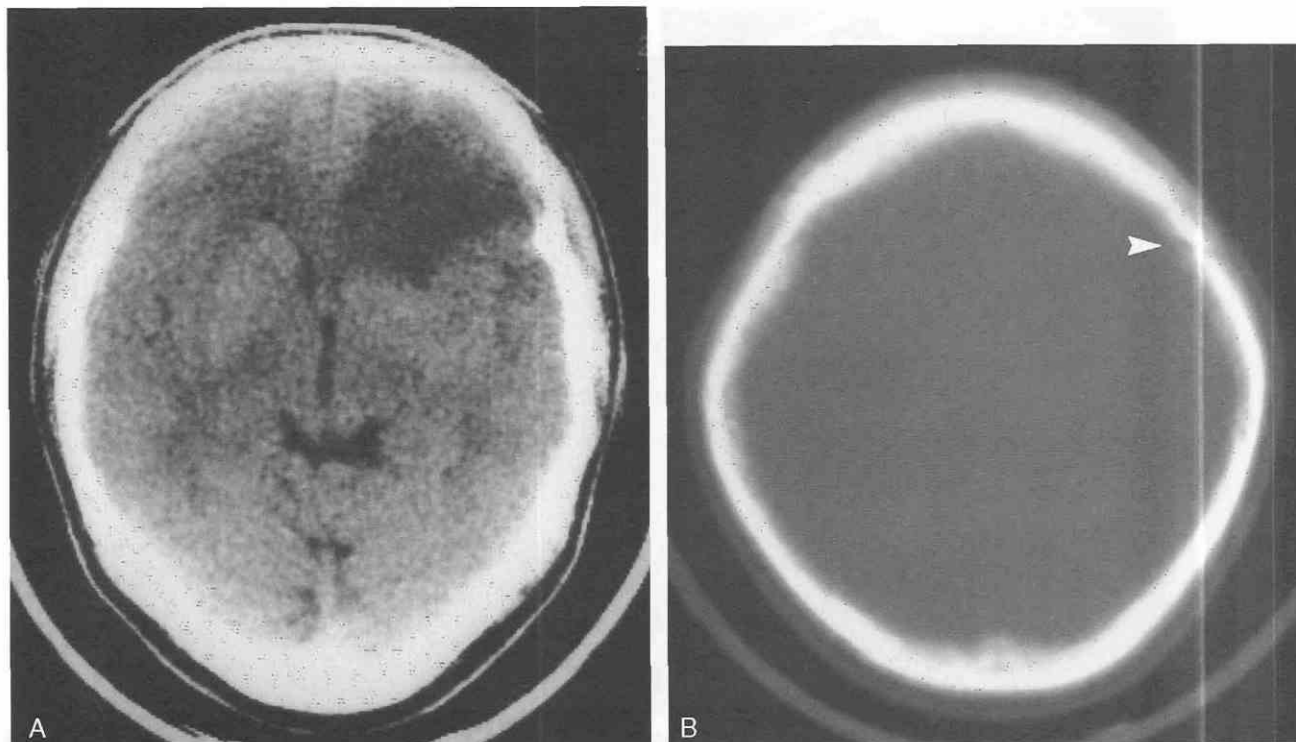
A, Infarction secondary to assault with a hammer. Unenhanced CT scan shows acute left frontal lobe infarction in the distribution of the left anterior cerebral artery. B, CT scan with bone window reveals nondepressed fracture of the left frontal bone (arrowhead).
